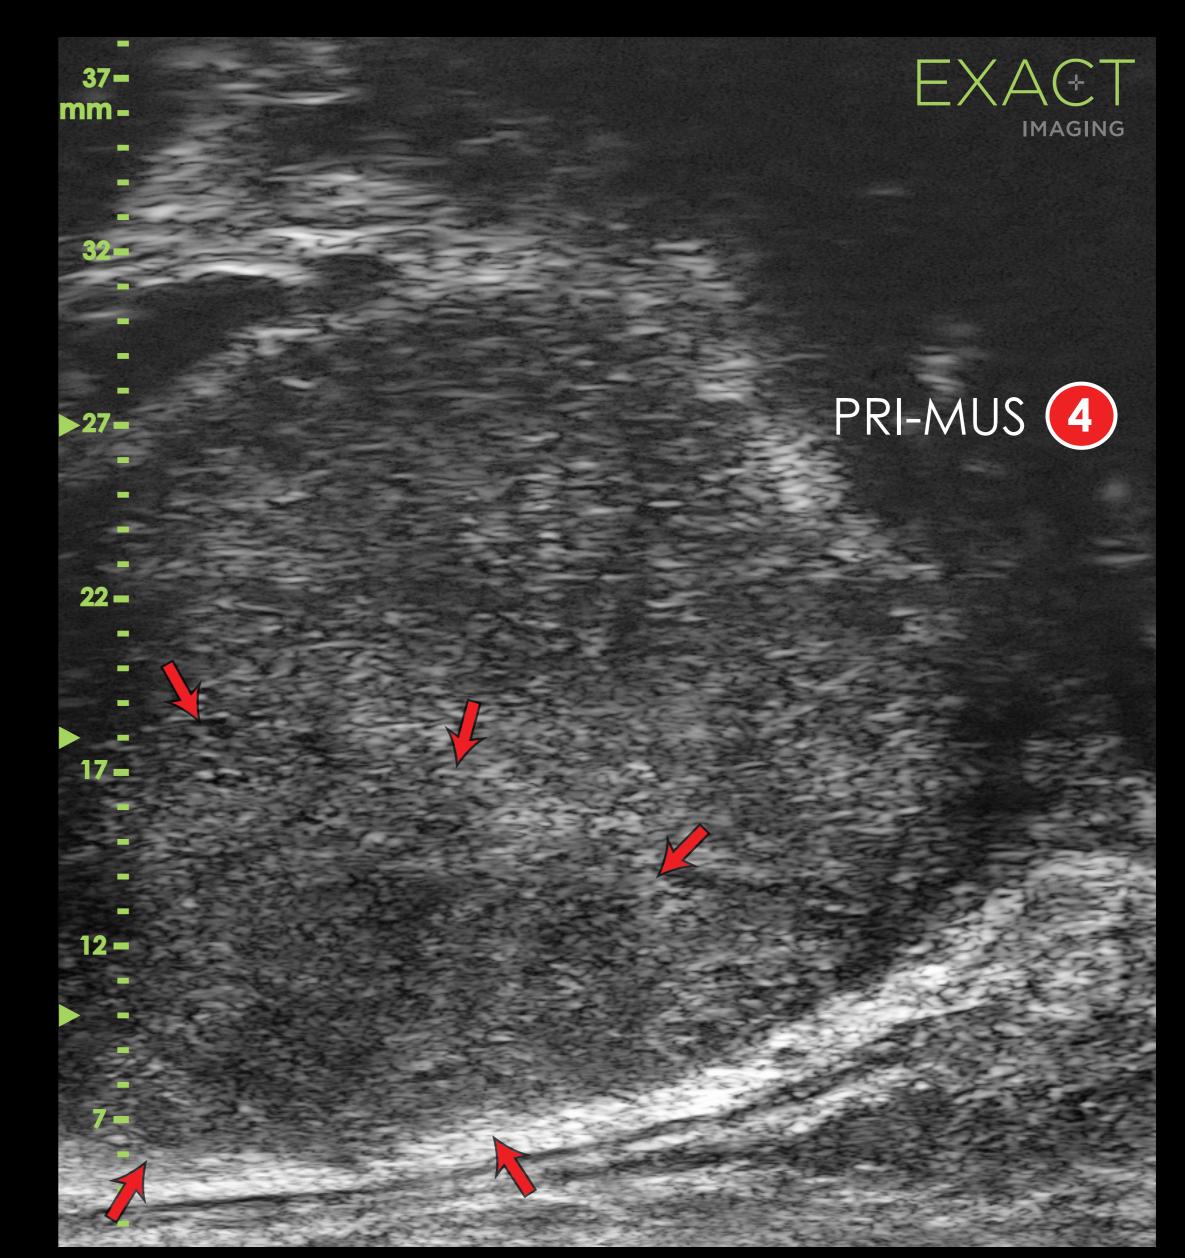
Parasagittal micro-ultrasound image of a PI-RADS 3 lesion in the right base medial aspect of the prostate.
